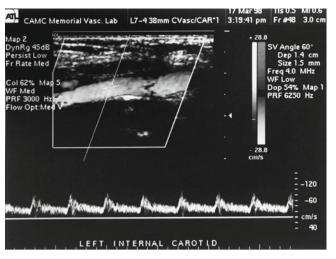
Color duplex ultrasound image of the internal carotid artery. Note that the waveform of the internal carotid artery has a rapid upstroke and downstroke with a high diastolic component. The diastolic notch may not be evident
